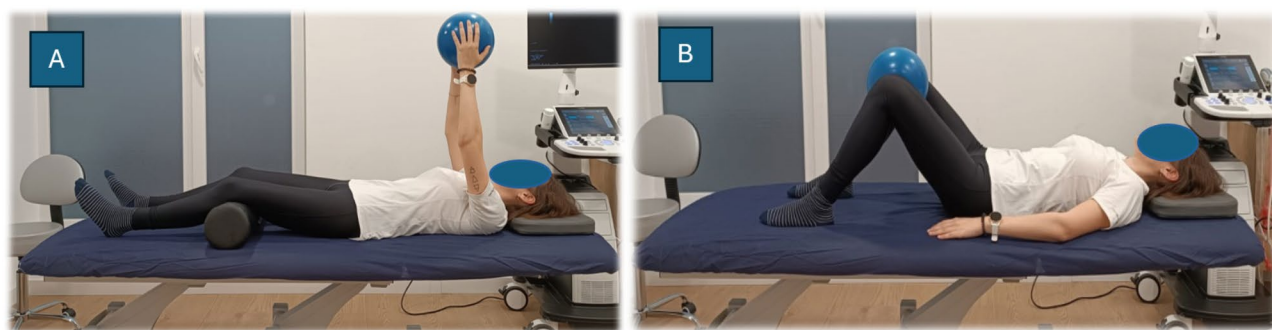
Position for ultrasound evaluation. A) During the upper limb adduction exercise with forced expiration. B) During the lower limb adduction exercise with forced expiration
